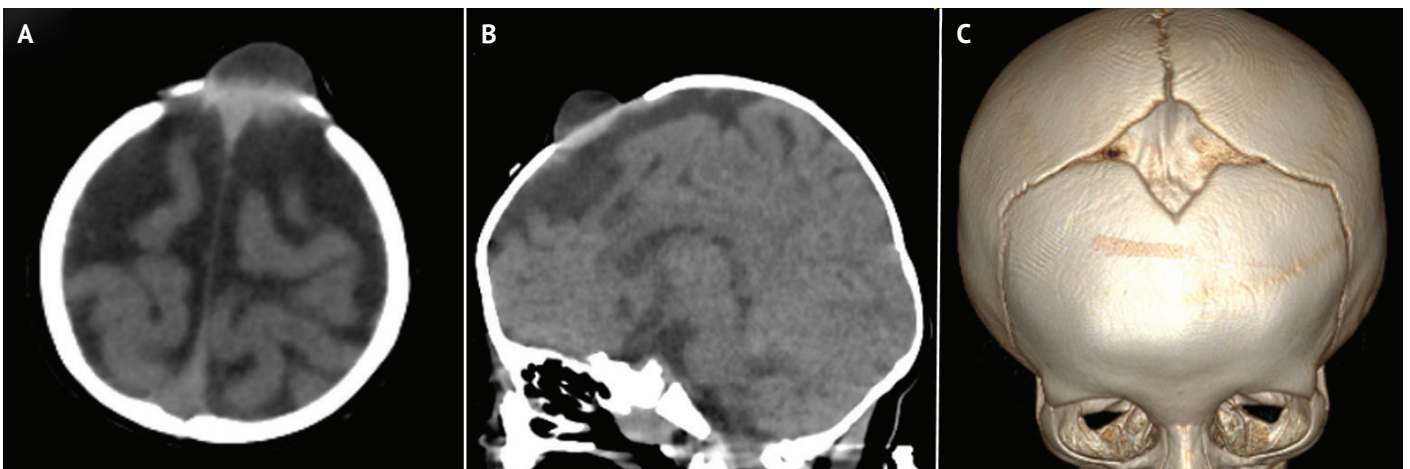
CT images of the anterior fontanelle dermoid cysts. (A) is axial, (B) is coronal image. (C) is 3D reconstruction of CT scan. Note that there is no bone flattening or erosion.
